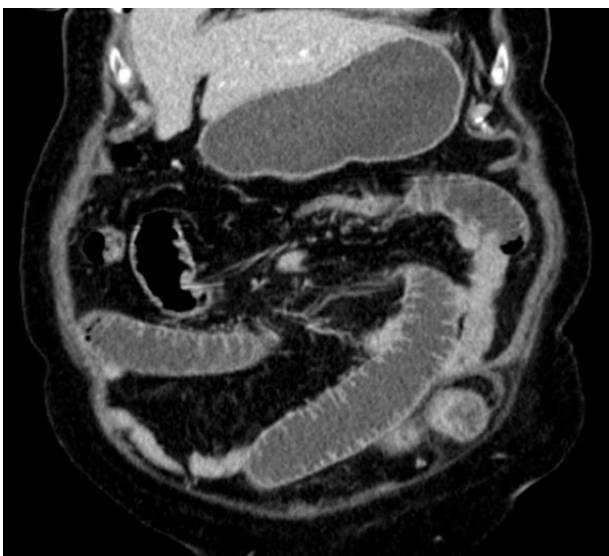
Computed tomography of incarcerated left SH with the external oblique aponeurosis intact and bowel distension.
